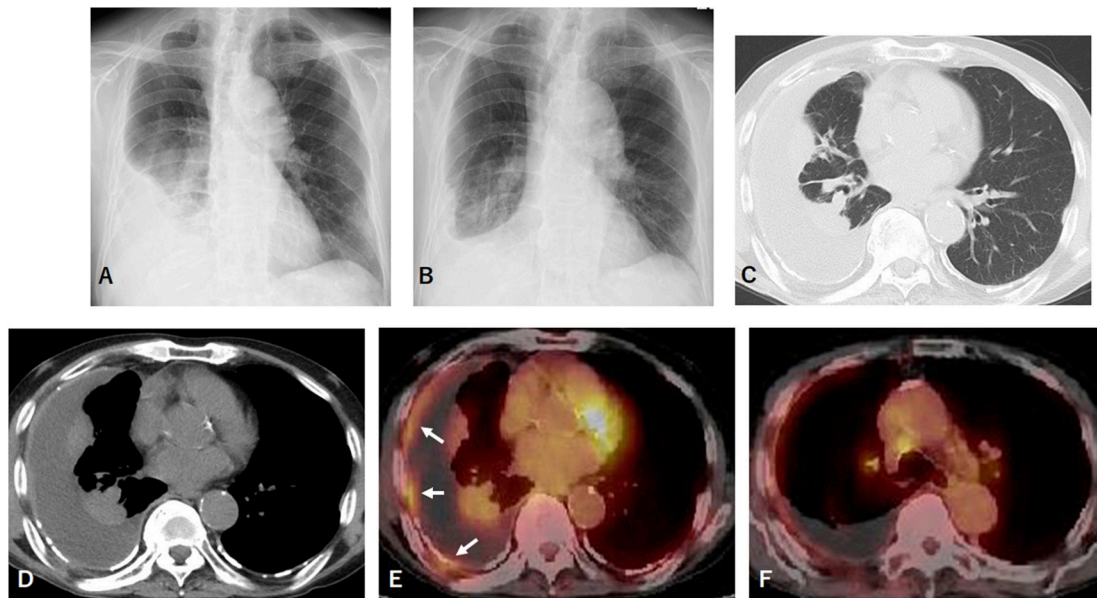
(A) Chest X-ray showing right pleural effusion at admission. (B) Chest X-ray showing improved right pleural effusion after 4 weeks of steroid treatment. (C, D) CT at admission day showing right pleural effusions with pleural calcification and tumor-like shadows induced by passive atelectasis. (E, F) PET showing fluid accumulation in the right thickened pleura (arrow), rounded atelectasis, and enlarged mediastinal lymph nodes.
